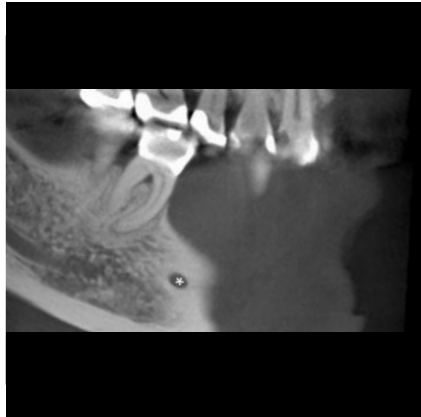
Sagittal CBCT image with mental foramen (*)
